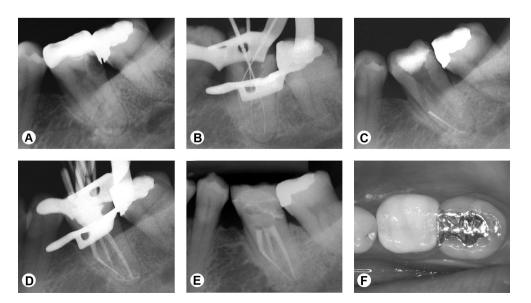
A: Preoperative radiograph. B: Radiograph of working length determination. C: Radiograph showing the fractured instrument in the mesiobuccal canal. D: Radiograph showing root filling procedures. E: Radiograph at 3-year follow up. F: Clinical aspect at the 3-year follow up.
